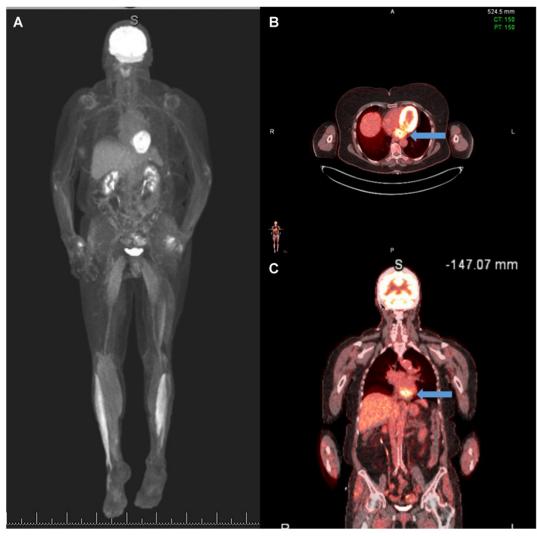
A FDG-PET scan with computed tomography overlay three-dimensional reconstruction, full-body display (A), demonstrates normal activity in the brain, kidneys, and bladder as well as lower and upper extremity soft tissues with abnormal increased FDG activity at the level of the heart. Axial display (B) demonstrates the FDG-avid tumor in the posterior pericardial space (*arrow*). Coronal display through the posterior pericardium (C) demonstrates the FDG-avid lesion in the posterior pericardium at the level of the AV groove (*arrow*).
